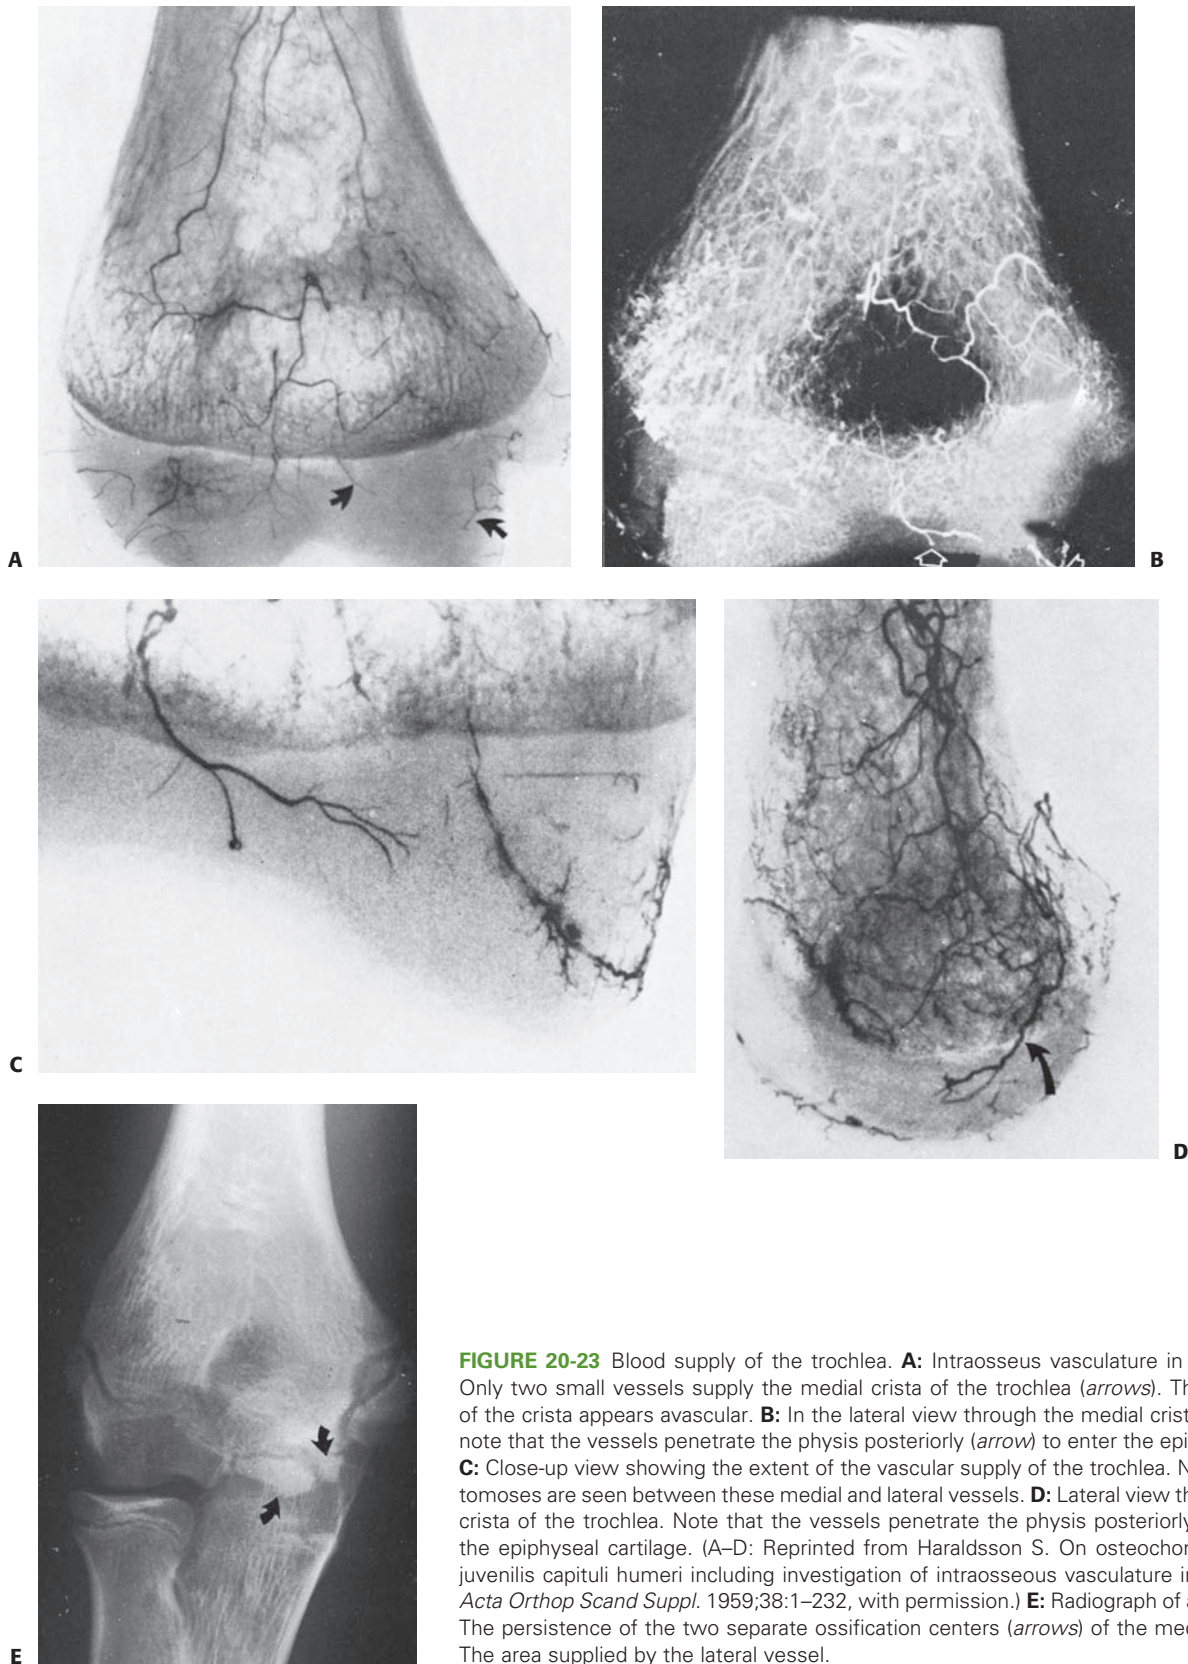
Blood supply of the trochlea. A: Intraosseous vasculature in a 3-year-old boy. Only two small vessels supply the medial crista of the trochlea (*arrows*). The central portion of the crista appears avascular. B: In the lateral view through the medial crista of the trochlea, note that the vessels penetrate the physis posteriorly (*arrow*) to enter the epiphyseal cartilage. C: Close-up view showing the extent of the vascular supply of the trochlea. Note that no anastomoses are seen between these medial and lateral vessels. D: Lateral view through the medial crista of the trochlea. Note that the vessels penetrate the physis posteriorly (*arrow*) to enter the epiphyseal cartilage. (A–D: Reprinted from Haraldsson S. On osteochondritis deformans juvenilis capituli humeri including investigation of intraosseous vasculature in distal humerus. *Acta Orthop Scand Suppl.* 1959;38:1–232, with permission.) E: Radiograph of a 12-year-old boy. The persistence of the two separate ossification centers (*arrows*) of the medial crista is seen. The area supplied by the lateral vessel.
